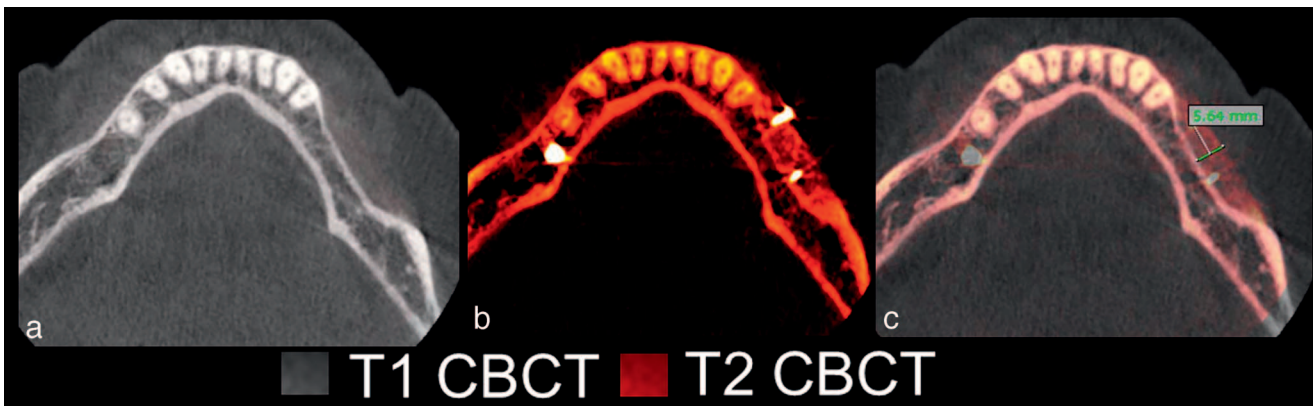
(a) T1 axial slice presurgery showing resorbed ridge. (b) T2 axial slice after horizontal bone graft. (c) T1 (gray) and T2 (red) axial slices superimposed showing the amount of bone gained after surgery. Because superimposition was done, the slices being compared are exactly the same. CBCT indicates cone-beam computerized tomography.
